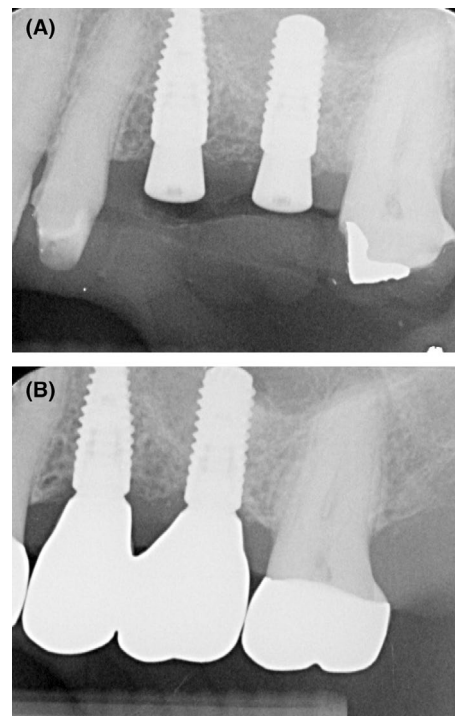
(A) This periapical radiograph was taken 3 months after the placement of 2 bone-level type implants in the maxillary left posterior segment. The implants were placed subcrestally and with a transmucosal healing protocol. Note the bone wall in proximity to the healing abutments. (B) The follow-up periapical radiograph taken 2 months after the prosthesis was connected shows early crestal bone loss (CBL) of 1 to 1.5 mm at both implants. Note the short abutments and wide restorative emergence angles (EA).
